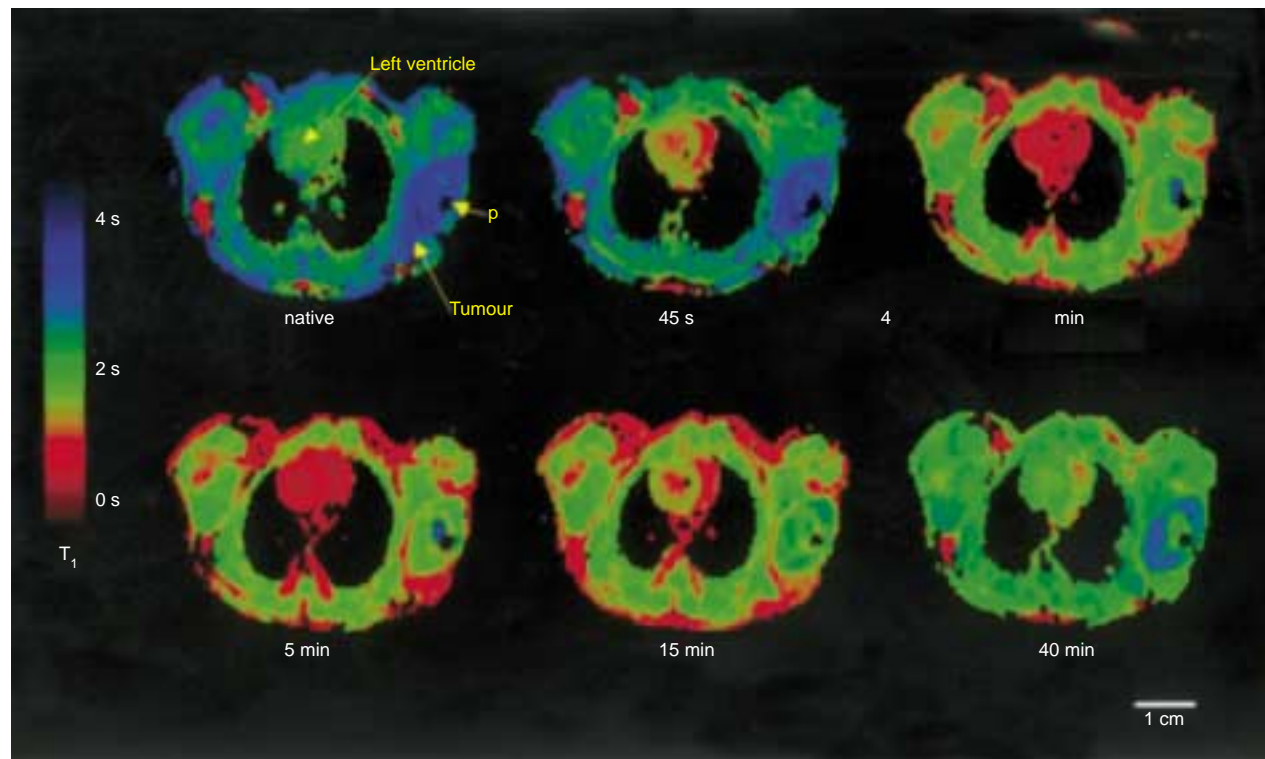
Representative transaxial colour-coded T_1 relaxation maps of a hamster before, during and after infusion of 0.05 mmol kg^{-1} b.w. gadopentetate dimeglumine (Gd-DTPA, 0.125 ml min^{-1} for 4 min). For MR imaging, an inversion recovery snapshot FLASH pulse sequences was applied (acquisition time: 2.5 s, in-plane resolution: 250 \times 250 μm^2 , slice thickness: 750 μm). From the Snapshot FLASH images, T_1 relaxation time maps were calculated pixel by pixel. Regions of interest (ROIs) were defined in the centre of the cavum of the left ventricle to characterize the arterial input function, and in the tumour for analysis of tumour blood flow. A pin (p) was implanted into the tumour to facilitate orientation of tumour sections
